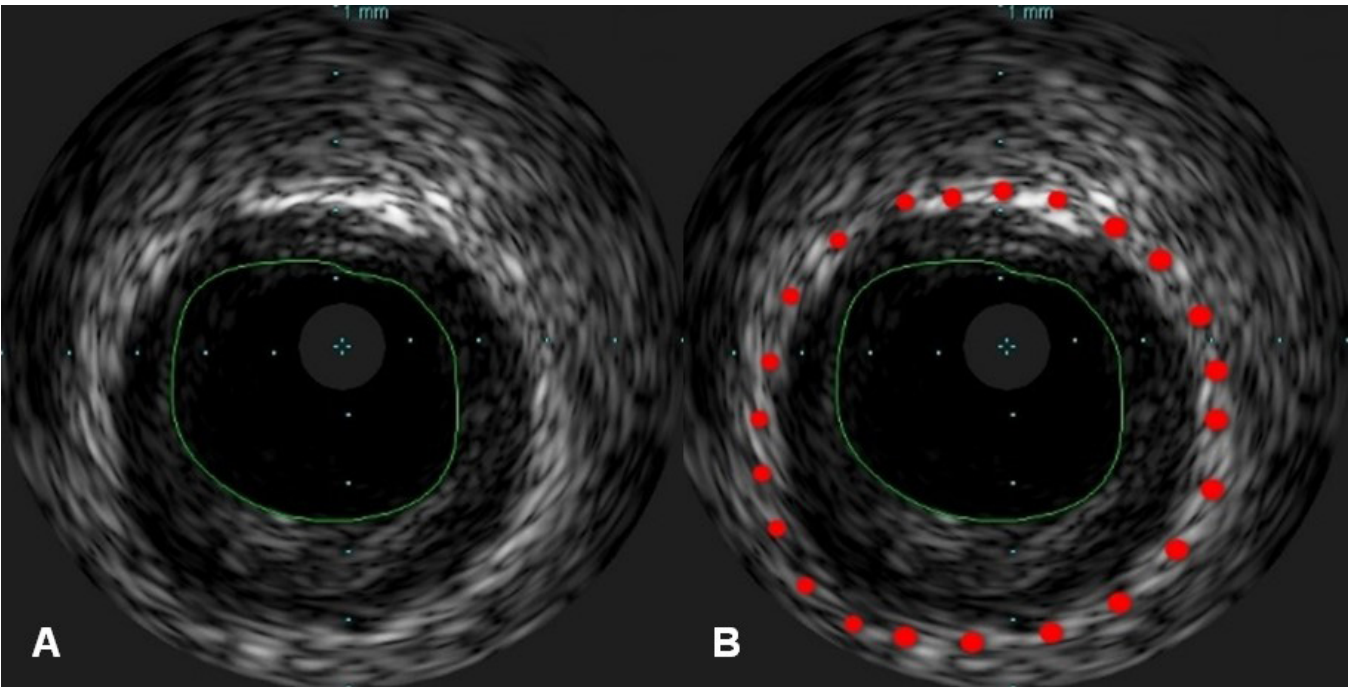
(A) An IVUS image of the coronary ostium. The grey circle in the middle points to the location of the ultrasound imaging catheter. The lumen is shown as a dark area (green circle). (B) Corresponding intravascular ultrasound image of the coronary artery with depicted adventitia (red circle).
